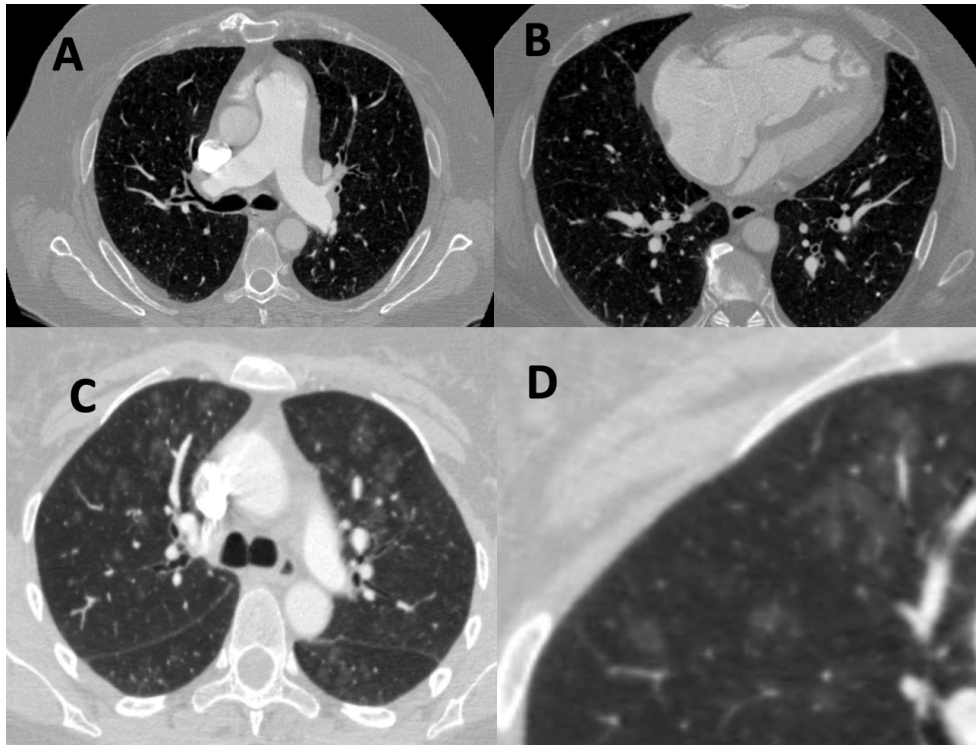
CT features of Pulmonary Arterial Hypertension (PAH) on CT. A - dilated main pulmonary artery. B - right atrial and ventricular dilation with moderate right ventricular hypertrophy and flattening of the interventricular septum. C - centrilobular ground glass nodularity. These are a feature of PAH, but are also more commonly seen in another sub-phenotypes of Pulmonary Hypertension, such as Pulmonary Vascular Obstructive Disease (PVOD). In PVOD, they are often accompanied by interlobular septal thickening and mediastinal lymphadenopathy. D – zoomed in view of regions of centrilobular ground glass nodularity.
